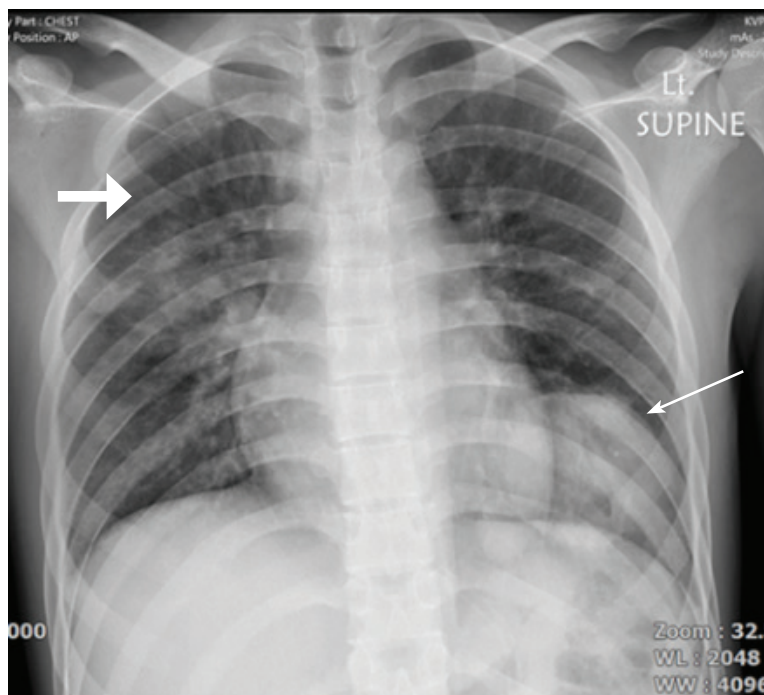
Chest postero-anterior plain film shows mass-like lesions at left lower lung zone (thin white arrow) and reticulonodulopatchy opacity at right upper-middle lung zone (thick white arrow). No cardiomegaly and/or pleural effusion is detected.
